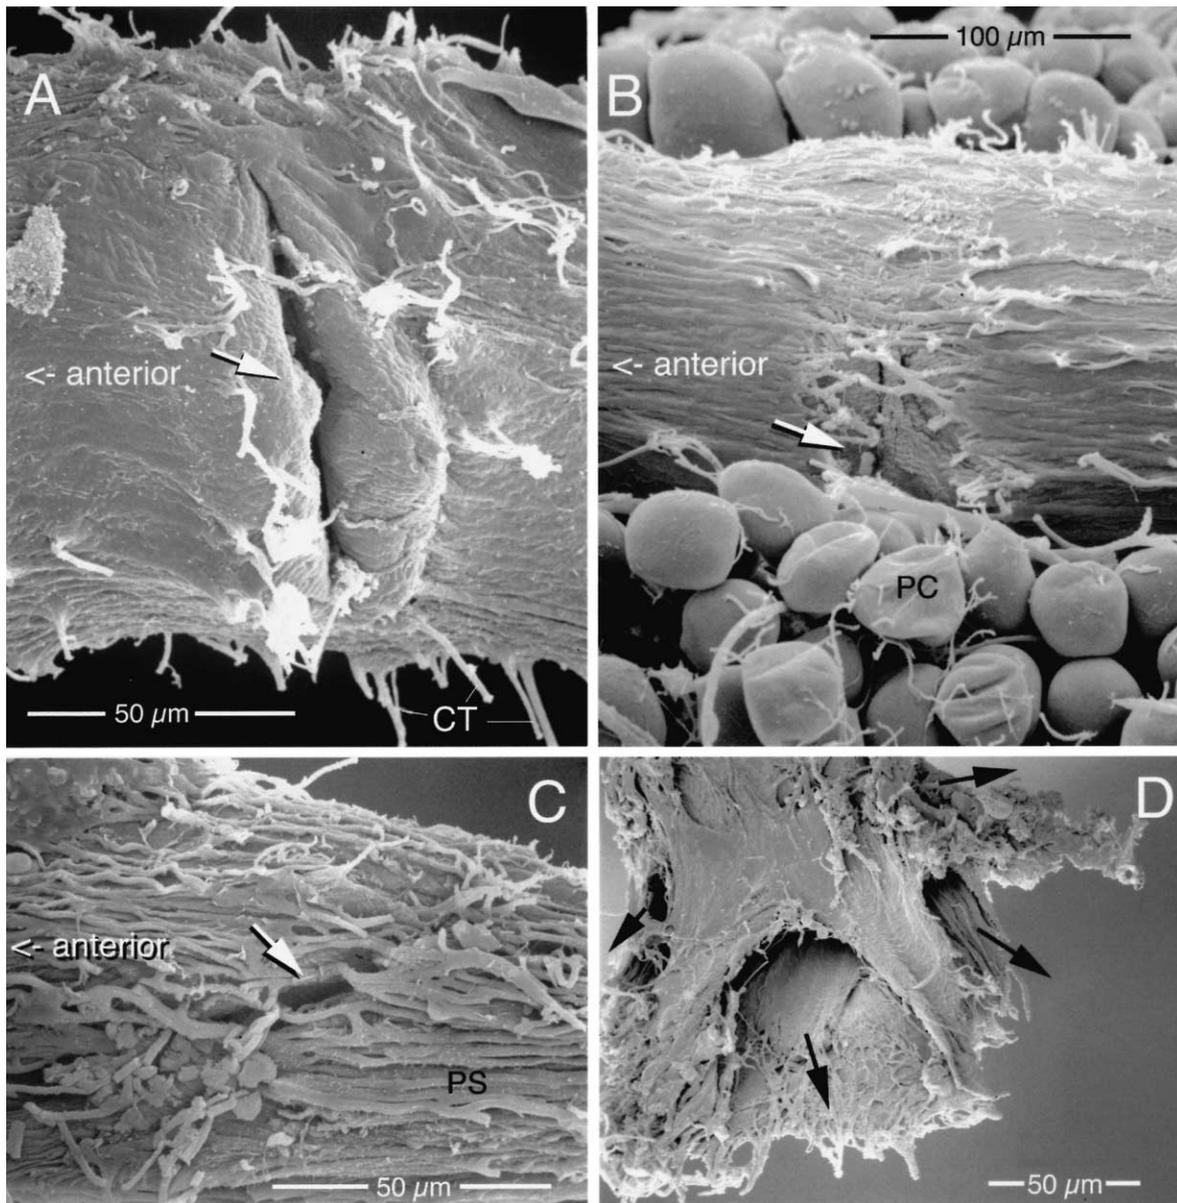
Posterior heart portion. SEM. (a) Lateral view of 3rd heart segment. (b) Ventral view of fourth heart segment. (c) Lateral view of fifth heart segment, covered by longitudinal muscles of pericardial septum (PS). (d) Dorsal view of posterior heart end with paired excurrent openings. Arrows show presumed outflow direction. CT = trabeculae of connective tissue; PC = pericardial cell.
